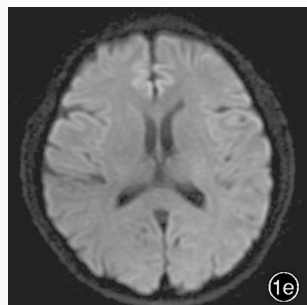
Head MRI findings Case 6, a 67-year-old male, was clinically diagnosed as ischemic stroke. Axial DWI showed a new infarct located in left pons (arrow indicates, Panel 1a). Case 3, a 46-year-old male, was clinically diagnosed as ischemic stroke. Axial DWI showed a new infarct located in the right posterior limb of internal capsule (arrow indicates, Panel 1b). Case 7, a 75-year-old female, was clinically diagnosed as ischemic stroke. Axial DWI showed a new infarct located in the left thalamus (arrow indicates, Panel 1c). Case 4, a 34-year-old female, was clinically diagnosed as ischemic stroke. Axial DWI showed a new infarct located in the left centrum semiovale (arrow indicates, Panel 1d). Case 9, a 61-year-old male, was clinically diagnosed as ischemic stroke. Axial DWI showed bilateral occipital lobes had no infarcts (Panel 1e).
